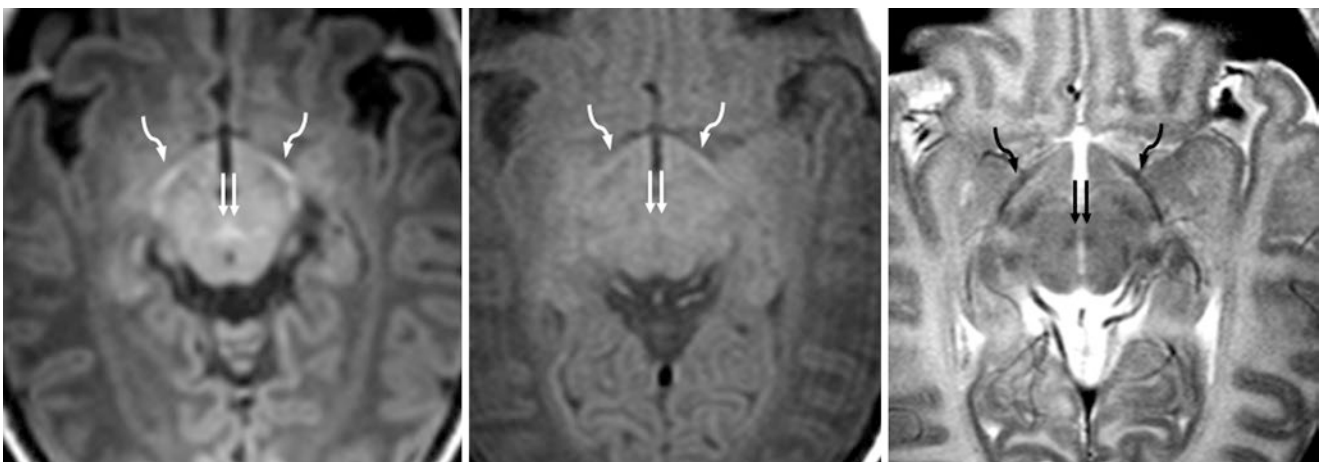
An 11-day-old term neonate had a normal 3T MRI with GE T1WI (*left*), SE T1WI (*middle*), and SE T2WI (*right*). The DSCP (*double arrows*) and optic tracts (*curved arrows*) appear myelinated. The myelination of these structures is not well visualized on SE T1WI
